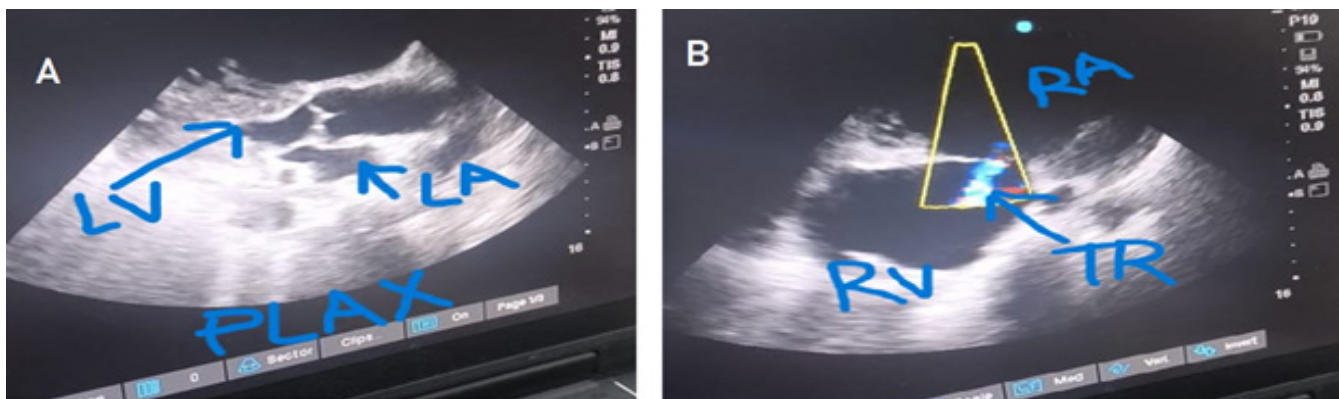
(A) Parasternal long Axis view (PLAX) showing left atrium (LA), left ventricle (LV) with mitral and aortic valve, (B) Four Chamber View showing dilated right atrium (RA, Green arrow), dilated right ventricle (RV, red arrow) with severe tricuspid regurgitation (TR, blue arrow)
